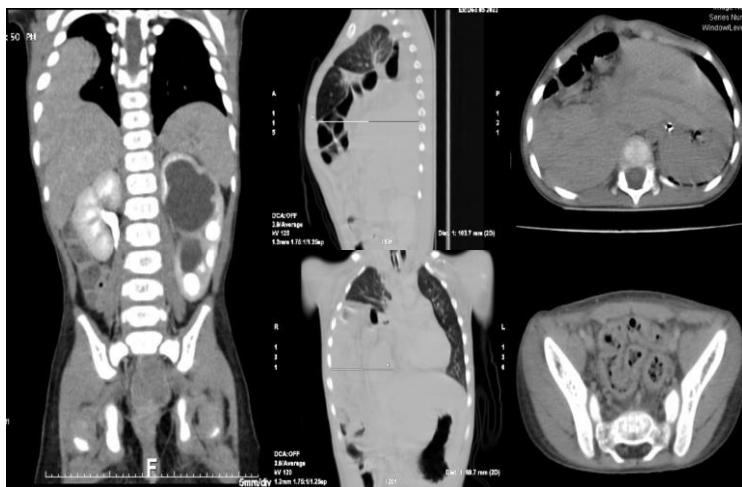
A thoracoabdominal contrast CT scan was also obtained and showed the impression of a right-sided diaphragmatic hernia, left grade II hydronephrosis, and sacral spina bifida
